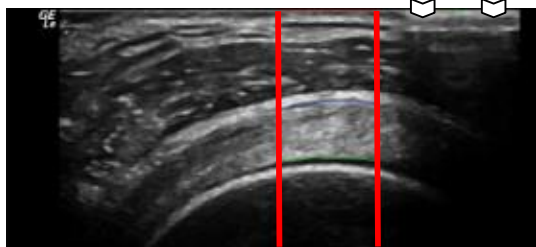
Transverse ultrasound image of supraspinatus tendon with region of interest between red vertical lines, selected based on the interference pattern (Σ) from a metal marker taped to the skin.
